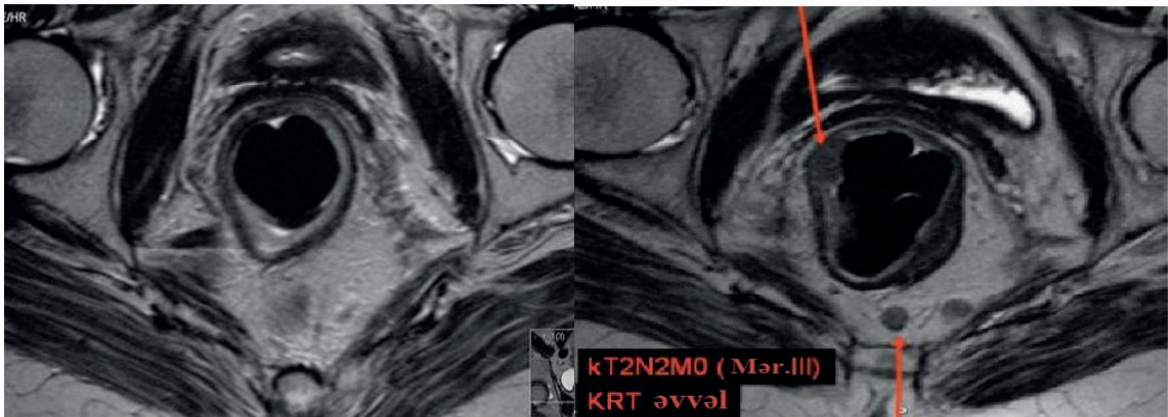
MRI images after radiotherapy
